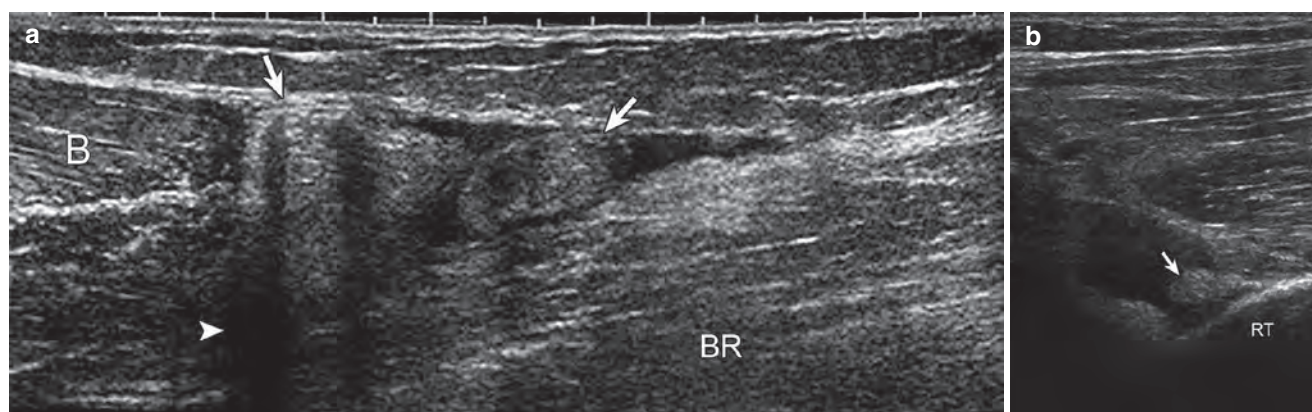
Biceps brachii: full-thickness tear. Ultrasound images show (a) proximal and (b) distal stumps of the torn and retracted biceps brachii (arrows). Note refractions shadowing (arrowhead) deep to recoiled
